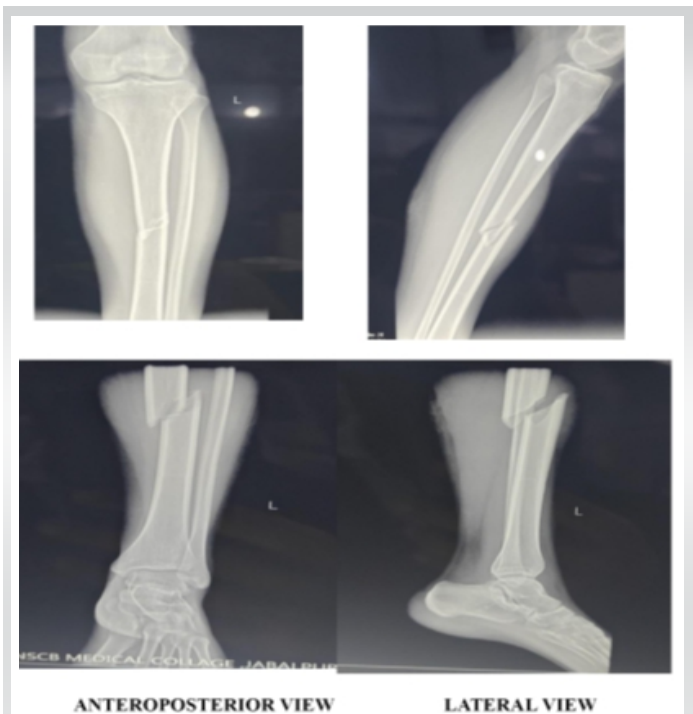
Pre-operative X-rays.
